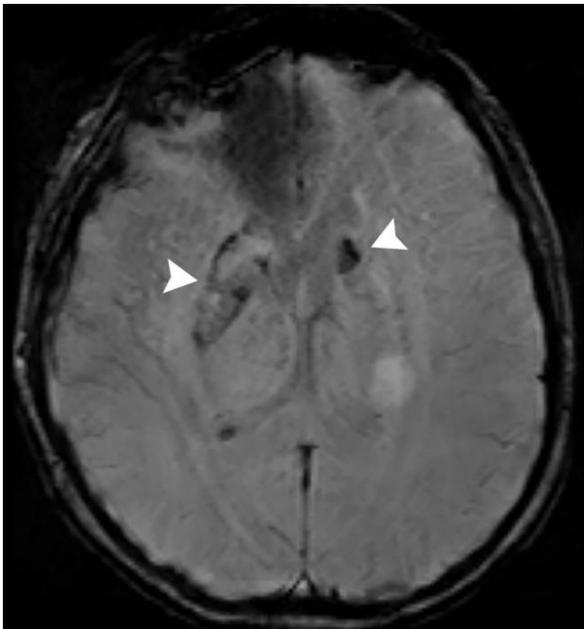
Brain MRI, axial SWI. Hypointense signal changes in the basal ganglia (arrowheads).
